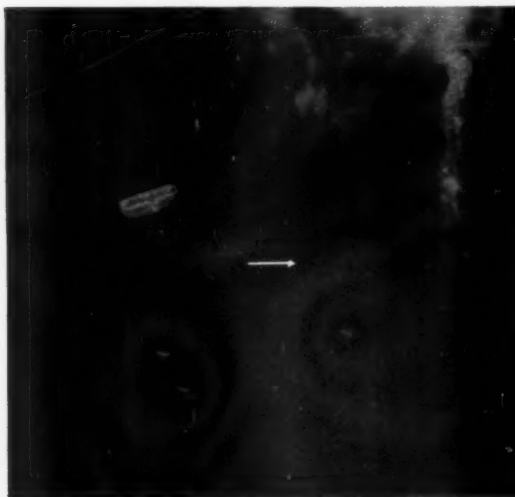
Case 1. X-ray before reduction, showing compression of eleventh thoracic vertebra.
